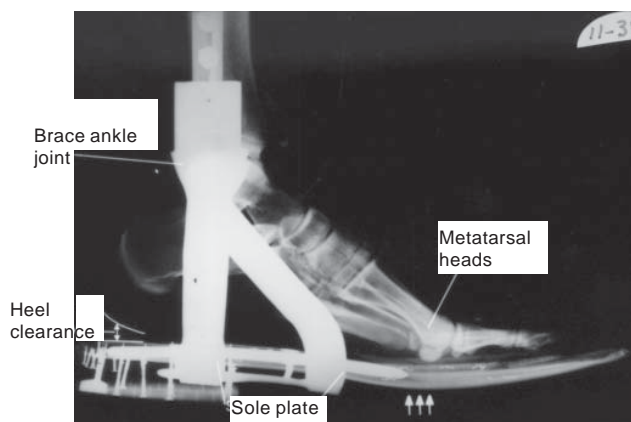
Radiograph of a foot in an ankle-foot orthosis.
